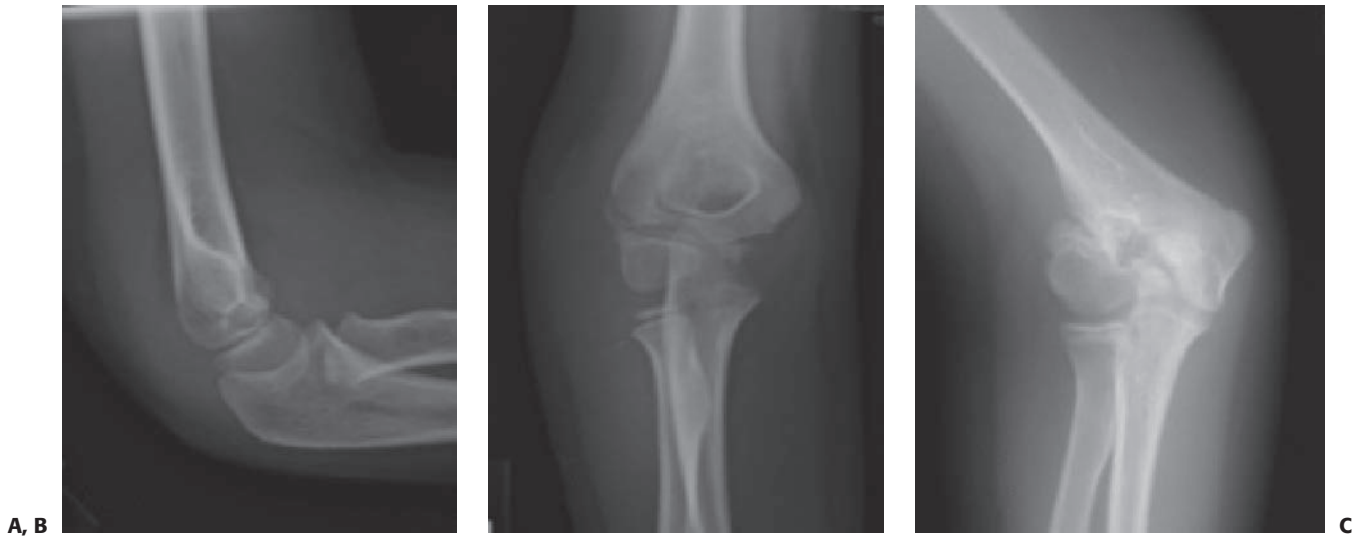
A: Lateral and (B) AP views at presentation demonstrating a minimally displaced lateral condyle fracture in a 4-year-old. C: AP radiograph in a 10-year-old with a prior lateral condyle fracture, now with nonunion and valgus deformity. (Property of UW Pediatric Orthopaedics.)
